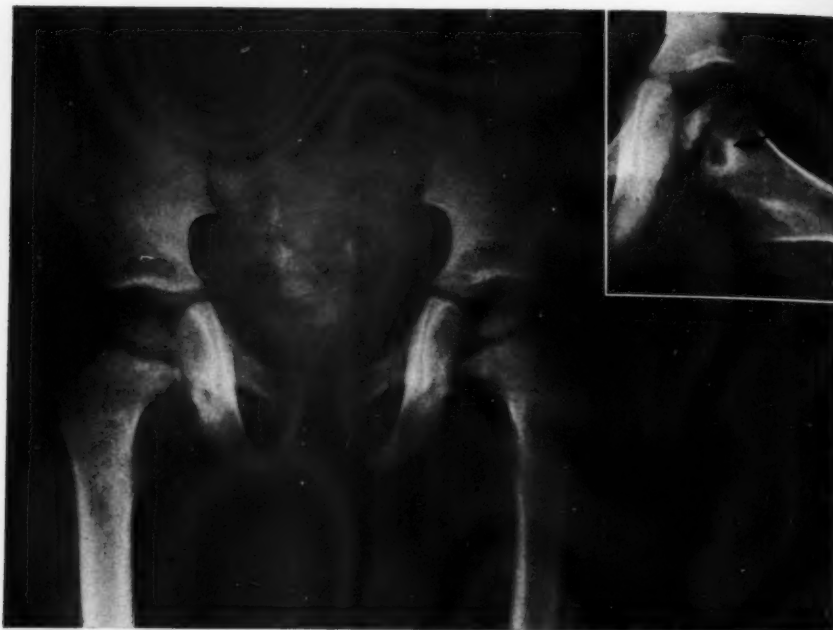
Case 10. Admission roentgenogram showing bilateral Legg-Perthes disease at age of three. There is a definite metaphysitis, which is well shown in the lateral roentgenogram (see insert). The hip joint spaces are definitely widened. See also Fig. 14, B-E.
